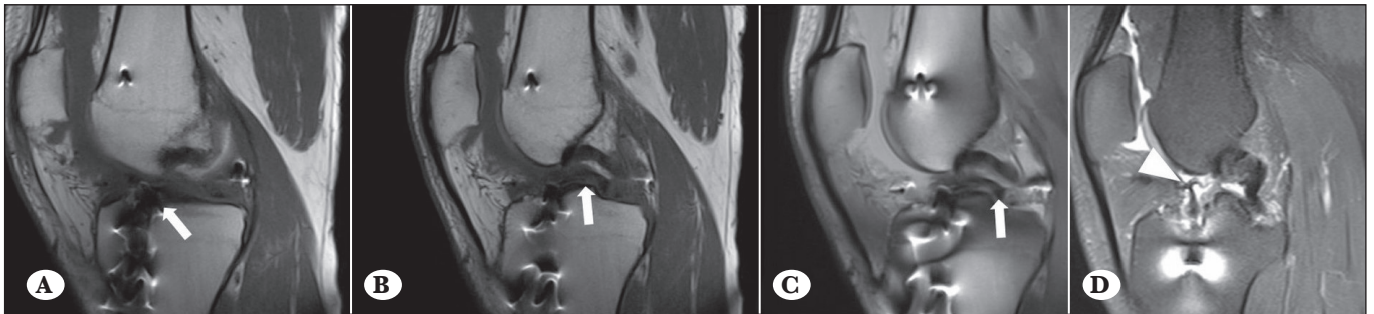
Sagittal T1-weighted consecutive MR images showing (A, B, C) vertical and anterior placement of the tibial tunnel and complete tear of the reconstructed ACL graft. ACL graft extending posterior-medial to the knee joint(arrow). Sagittal PD-weighted fat suppressed MR image showing (D) decrease in graft size in the middle of the ACL graft (arrow head) when compared to the proximal and distal part (partial graft tear of ACL graft).
